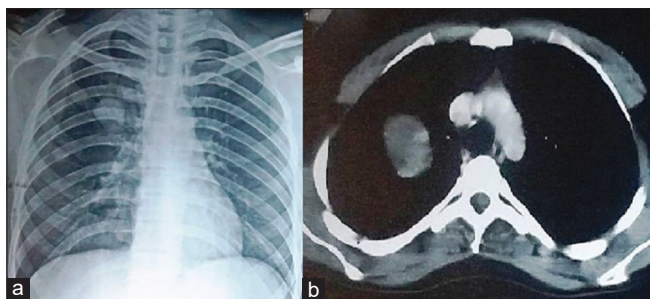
X-ray chest (a) and computed tomography chest (b) showing a well-defined rounded opacity at right upper lobe
